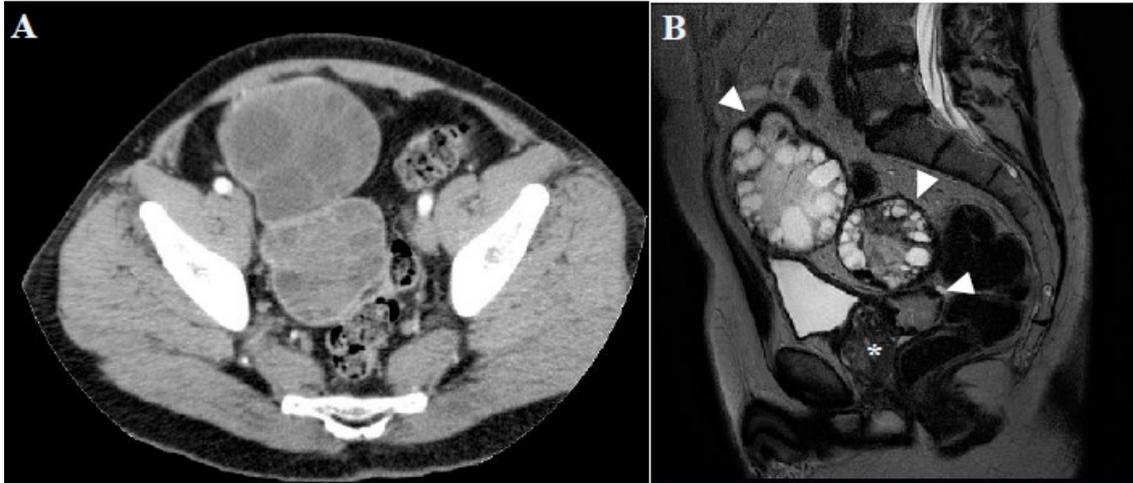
A. Contrast-enhanced axial multidetector CT (MDCT) revealed two pelvic rounded and well-defined lesions that contain multiple cysts due to daughter cysts. B. A MRI sagittal T2- weighted image shows the pelvic cystic masses with daughter cysts attached to the periphery. The lower hydatid cyst makes contact with the prostate gland (asterisk). Note the low-signal-intensity rim (rim sign) that represents the pericyst (arrowheads).
